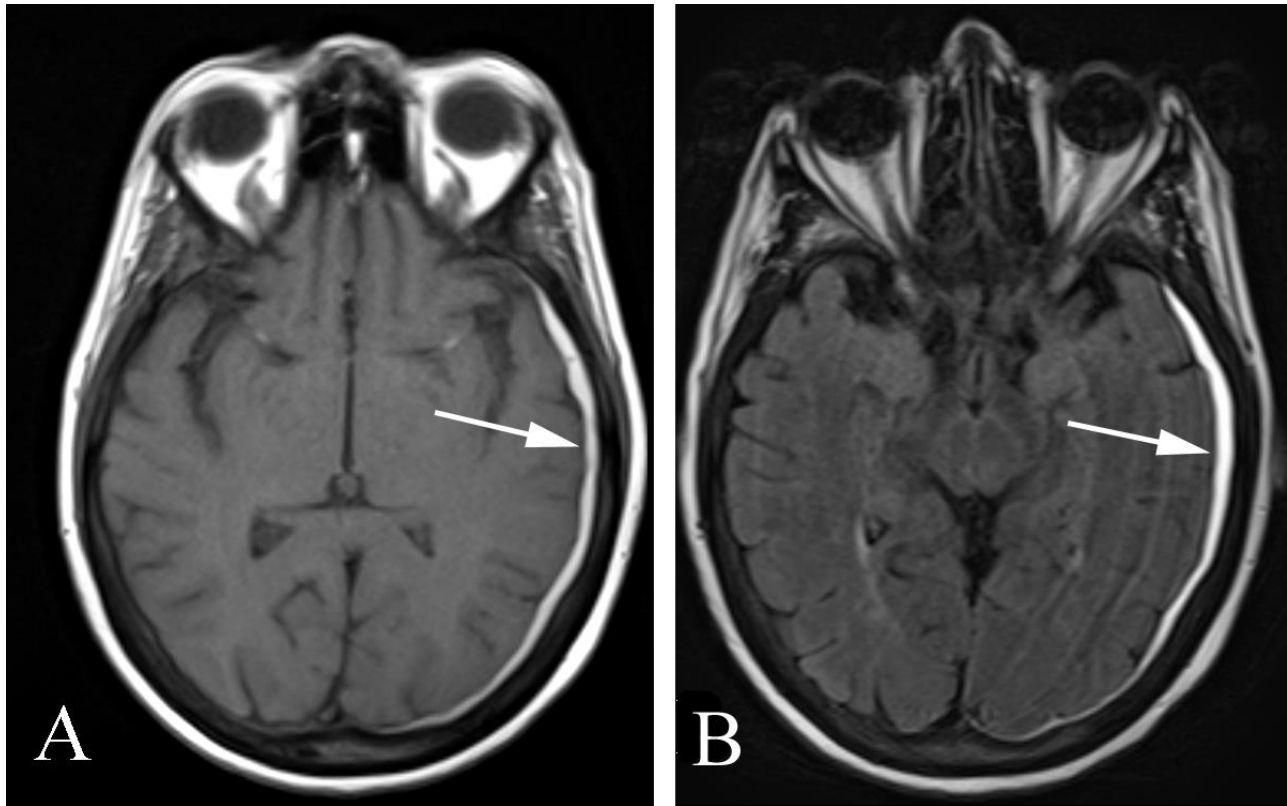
Subdural hematoma in a 60 year old anticoagulated woman with new seizures. A. Axial unenhanced T1 weighted MR image shows a crescent of increased signal along the left cerebral hemisphere (arrow), typical of a subdural hematoma. B. Axial FLAIR image also demonstrates a crescent of increased signal along the left cerebral hemisphere (arrow).
